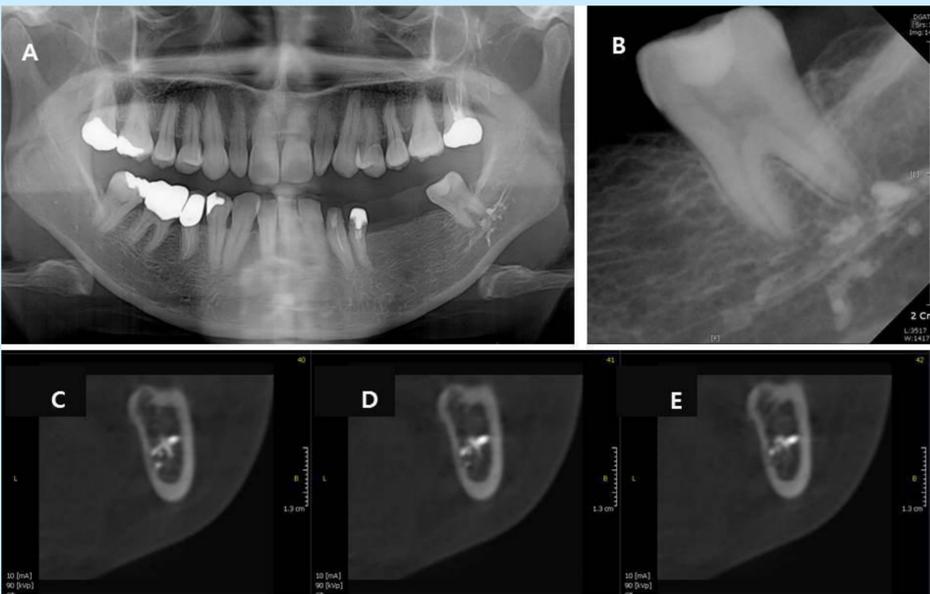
Panoramic view of the patient after extrusion of calcium hydroxide. Increased radiopacity around periapical area of #37 and left inferior alveolar canal is seen.
